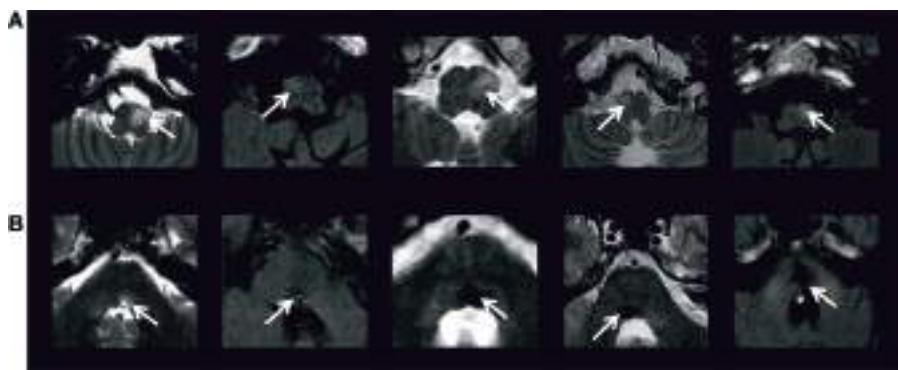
Axial FLAIR or T2 MRI (1.5-T GE scanners) at (A) inferior olive level and (B) midpontine tegmentum level in five patients with symptomatic oculopalatal tremor. White arrows in (A) indicate the abnormal inferior olive hypersignal and in (B) the causative lesion. Adapted from Ref. (24).
